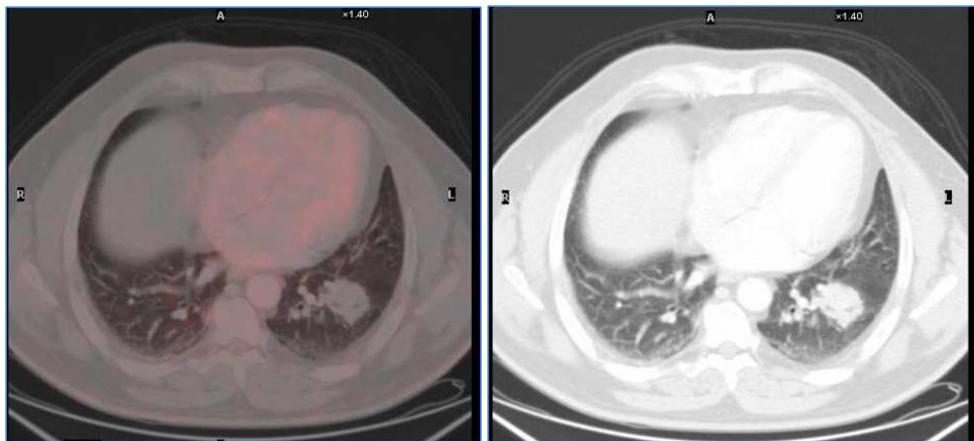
Axial sections of CT and PET/CT combined image. Lesion on the lower right lobe with air bronchogram, without ¹⁸FDG uptake. False negative: Bronchioalveolar carcinoma.
